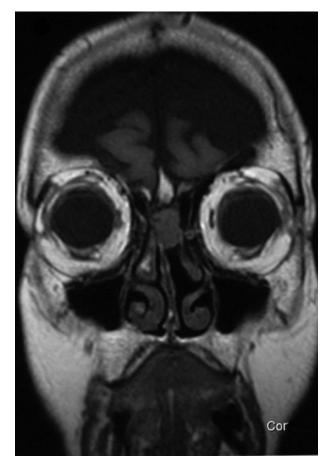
MRI scan showing the soft tissue mass arising from the nasal septum.
